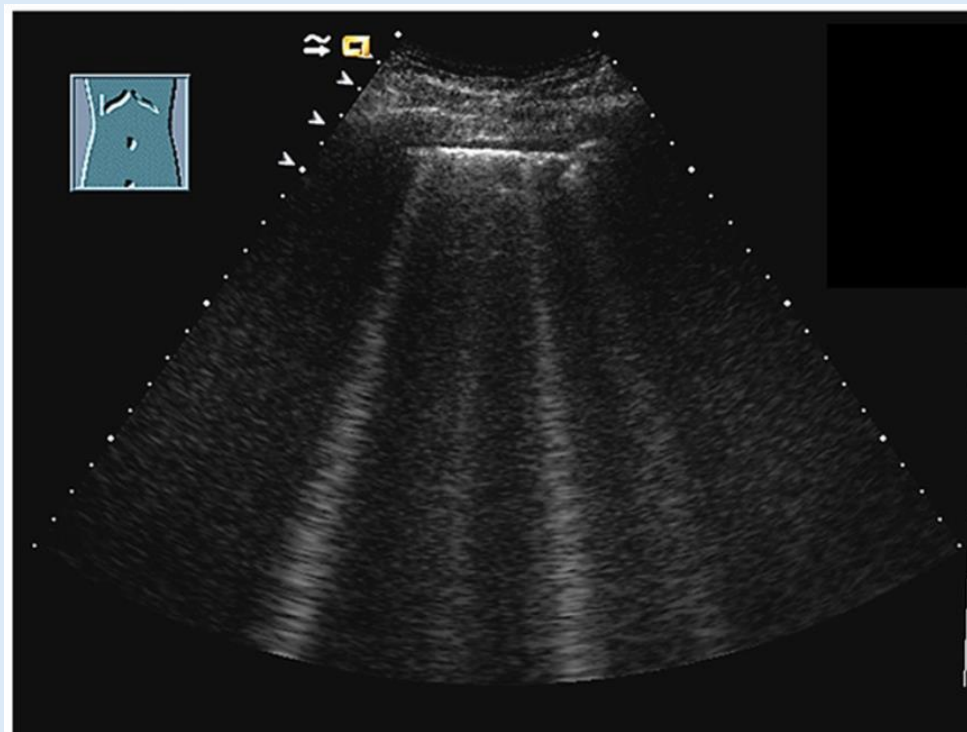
Four B-Lines on Ultrasound, re-used with permission (2)
